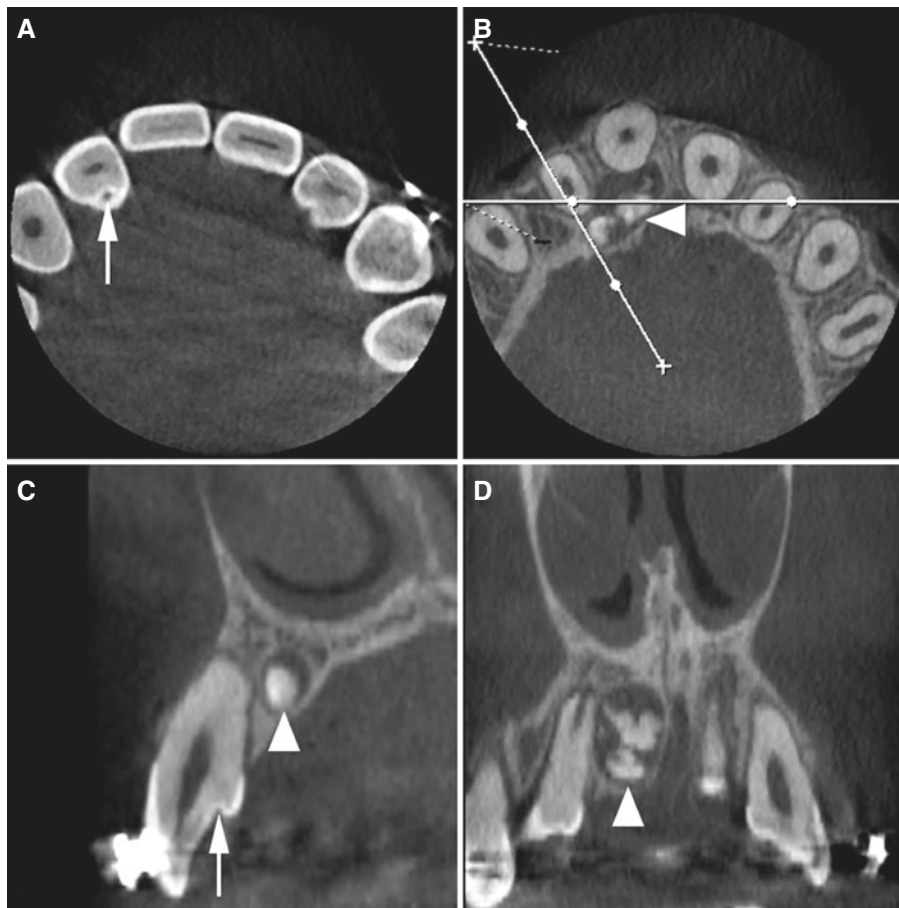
Foramen cecum, lateral incisor and odontoma, maxilla; 12-year-old female with incidental finding. (A) Axial, (B) axial (with cursor lines), (C) oblique sagittal, and (D) coronal CBCT images show
